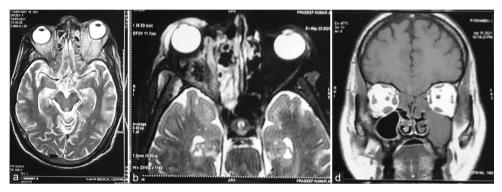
(a) Contrast-enhanced magnetic resonance imaging (CE MRI) axial section showing tenting of the globe, (b) CE MRI axial section showing hypointense collection in myofascial space, and (c) MRI coronal section showing bulky right and inferior recti muscles
